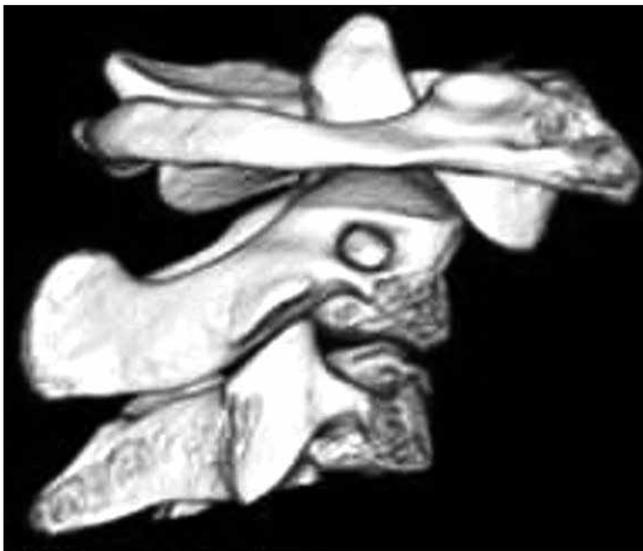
Three-dimensional reconstruction CT scan showing anterior displacement of atlas.
